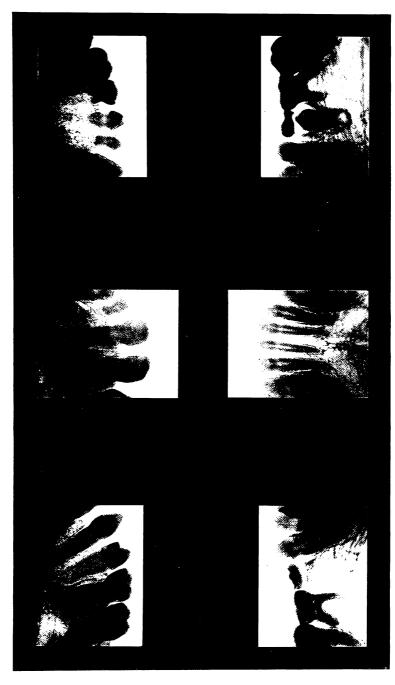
Same case as Fig. 303 fourteen days later, after attempt to open the maxillary suture. (Radiographed by Lodge, of Cleveland.)
